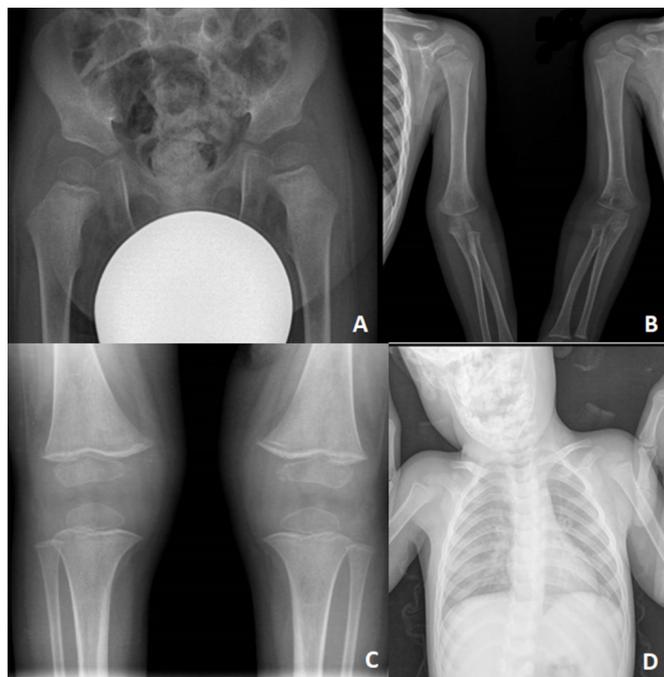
Whole-body radiography of patient 1 shows a reduced calcic tone and radiotransparent bands under the metaphyseal plate of femur necks bilaterally (A) and dense iuxtaphyseal bands alternating with radiotransparent ones in the metaphyseal regions of humerus, radius, ulna (B), femur, tibia and fibula (C). In (D), note the widening of costochondral junction.
